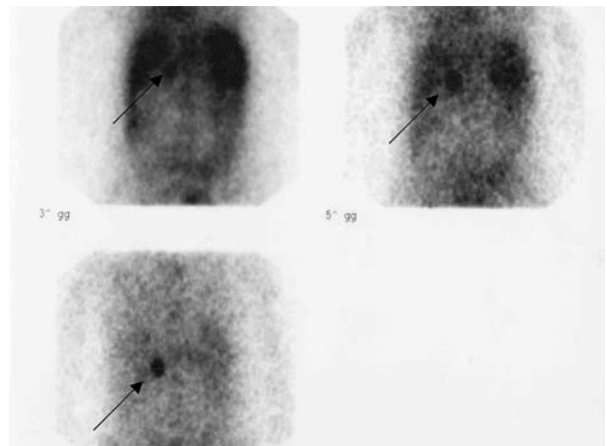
Radioiodine (131 I)-norcholesterol adrenal scintigraphy: arrows indicate the precocious and late uptake of radiotracer at right adrenal gland level. No uptake was found at the controlateral gland.
